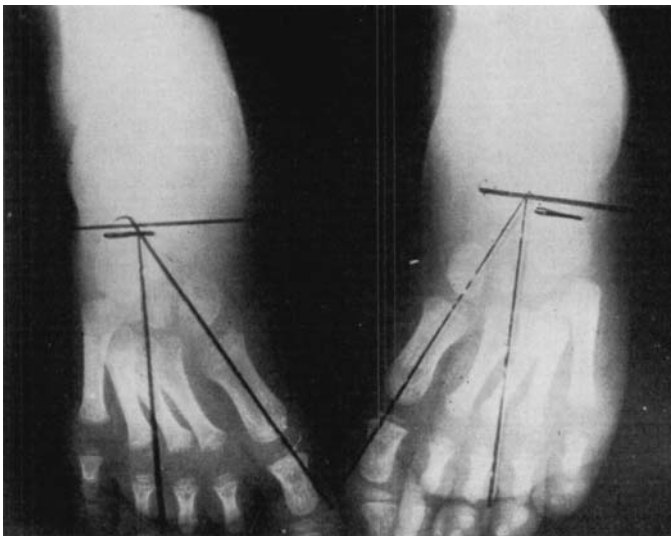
Adduction of the forefoot measured on the antero-posterior X-ray as the angle of deviation from a line perpendicular to the calcaneocuboid joint.
